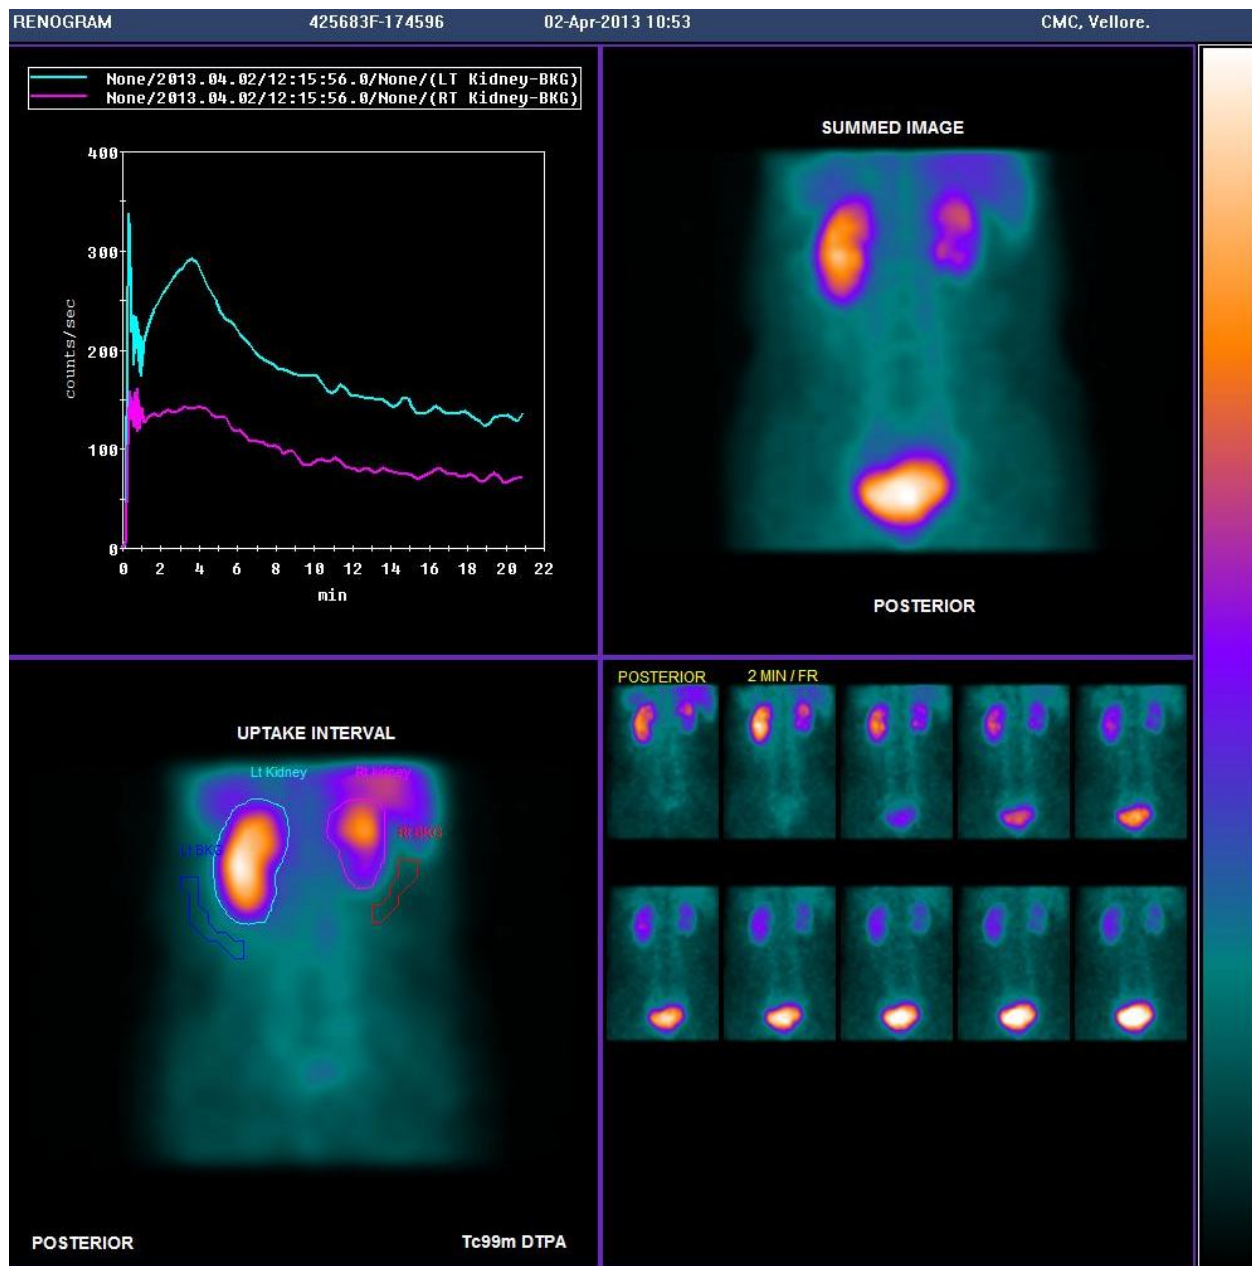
Tc99m DTPA renal scintigraphy shows a dominant left kidney. The relative functional difference between both the kidneys was more than 20%.
